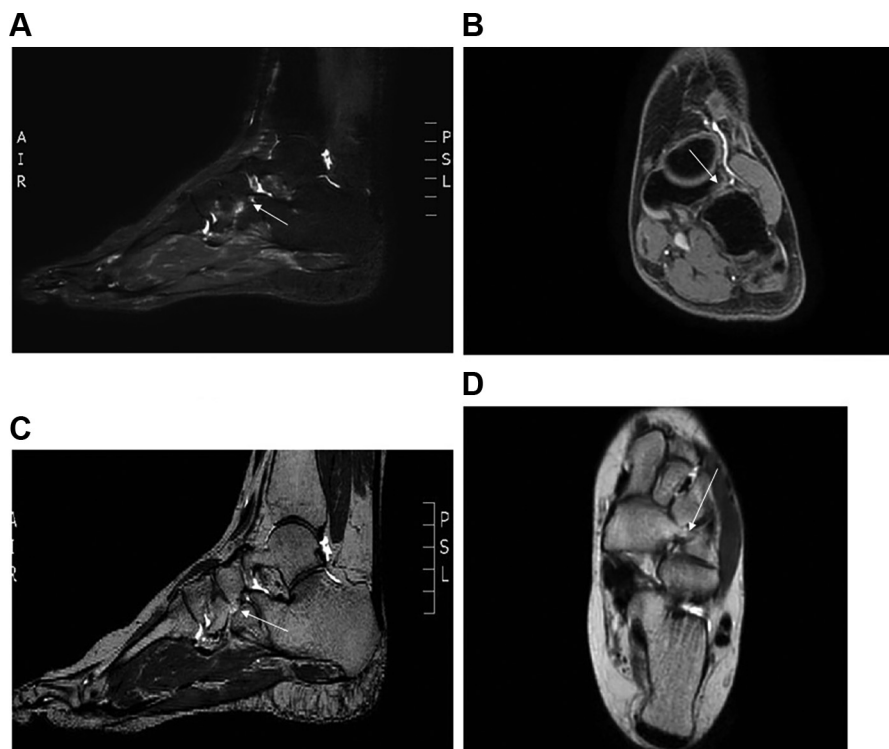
(A and B) Sagittal and axial T1-weighted magnetic resonance images demonstrating bone marrow edema adjacent to the joint and bony margin irregularities between the cuboid and navicular bones (white arrows). (C and D) Sagittal and axial T2-weighted magnetic resonance images demonstrating a fibrocartilaginous bar of intermediate hyperintense signal between the cuboid and navicular bones (white arrows).
